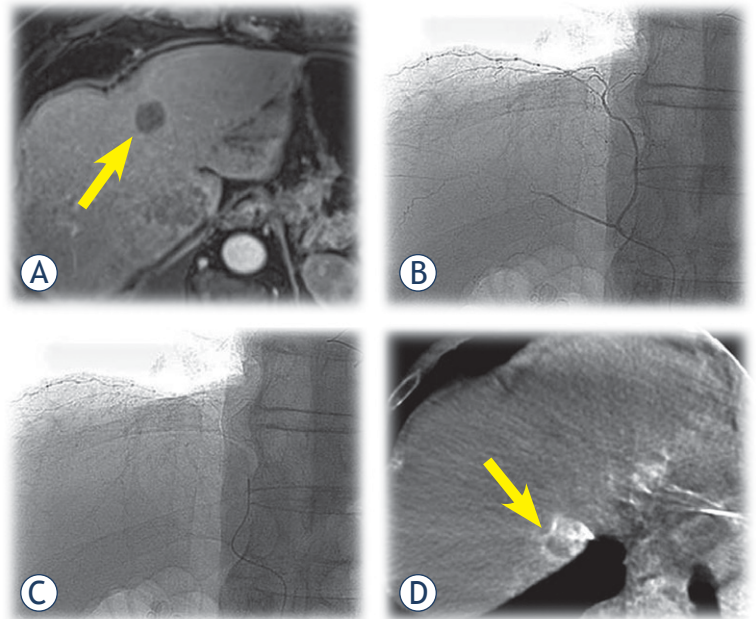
A 64-year-old male with HCC. (A) Control MR after chemoembolization shows complete response of the target lesion (arrow) in fourth segment and partial response of the target lesion in eight segment. (B) Superselective contrast injection through microcatheter into the right phrenic artery. (C) Position of microcatheter prior CBCT. (D) CBCT shows that this artery supplied the target tumor in seventh segment. Superselective DEBDOX TACE was performed.
